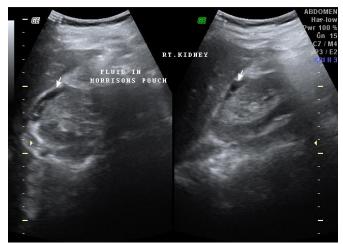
Ultrasound image showing ascites.
